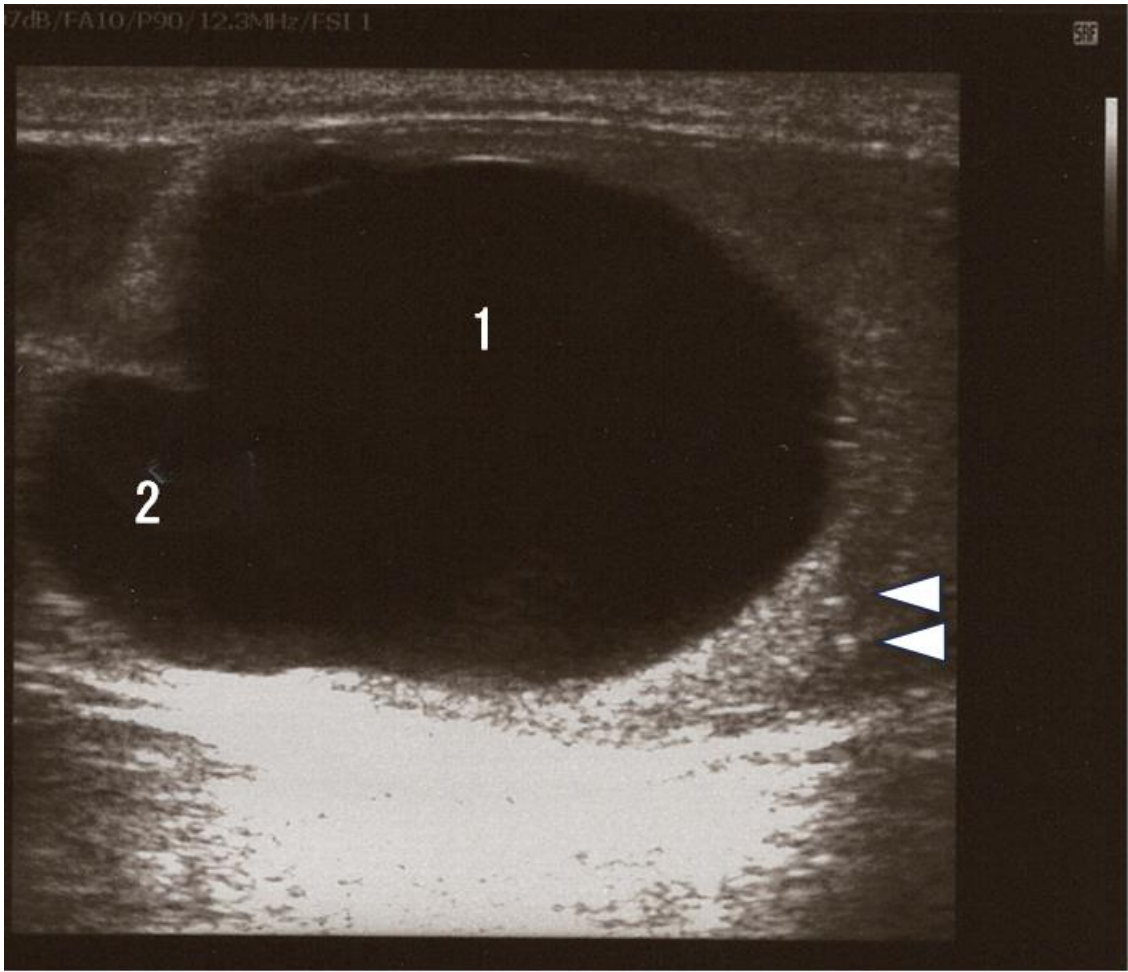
Ultrasonography of the left testis. A 3.2-cm main cyst (1) and a 2.3-cm cranial cyst (2) are present. The septum between the cysts is thin and not clearly visualized. Posterior acoustic enhancement is present. Numerous microliths are seen in the testicular parenchyma (arrowheads).
